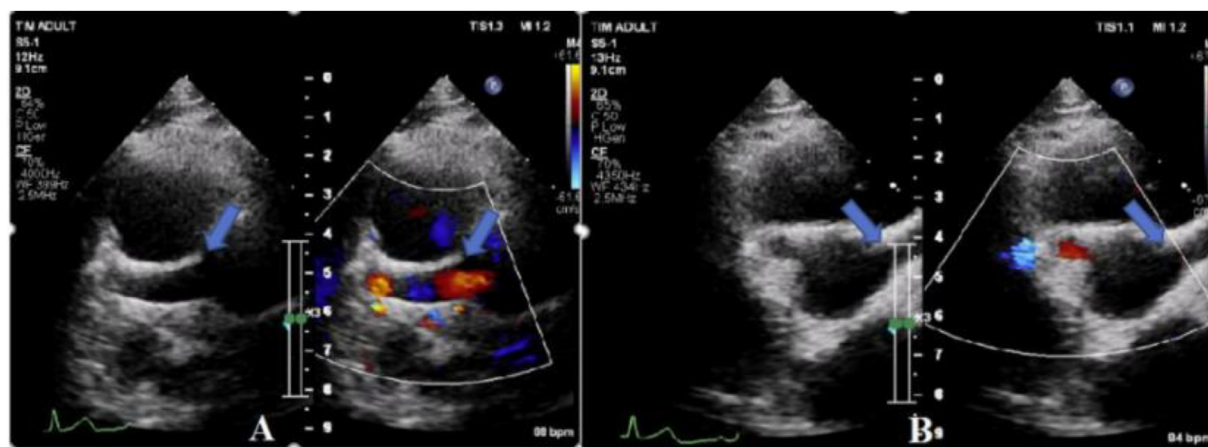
The echocardiography showed the LCA originating from the pulmonary artery (blue arrow) (A). The origin of the LM is from the posterior to the right of the MPA, very close to the ascending aorta, mimicking the normal origin of the LM from the aortic root. This cross-section appears to show the origin of the LCA, but it is a dropout artifact (blue arrow) (B).
